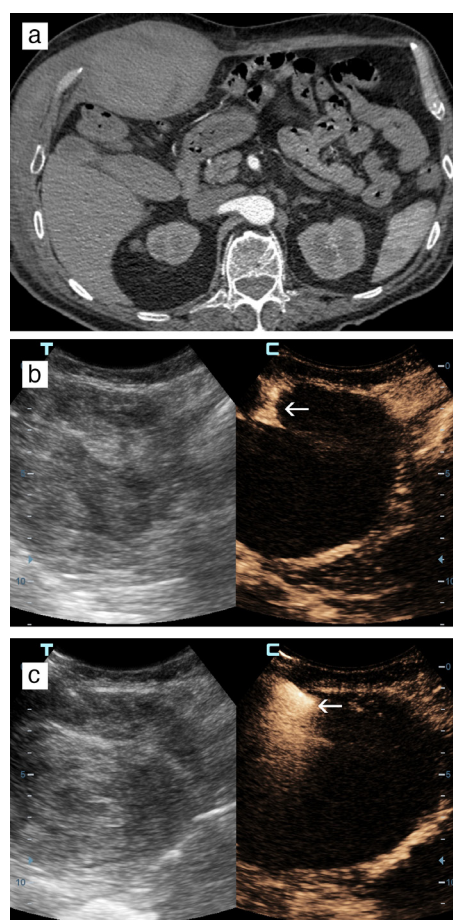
(a-c) Case 2. Axial section of contrast-enhanced CT (arterial phase) pre-intervention: (a) shows the right rectus sheath hematoma. No signs of active extravasation. Sonographic “dual screen” image (unenanced, reference, gray-scale image on the right; CEUS image on the left) pre-intervention; (b) shows clearly a triangular-shaped extravasation (arrow). Sonographic image (same configuration as previous image) during PTI; (c) shows the Chiba needle, which has reached the proximal part of extravasation, and thrombin injection as linear and punctate echogenicities (arrow). CT, computed tomography; CEUS, contrast-enhanced ultrasound; PTI, percutaneous thrombin injection.
